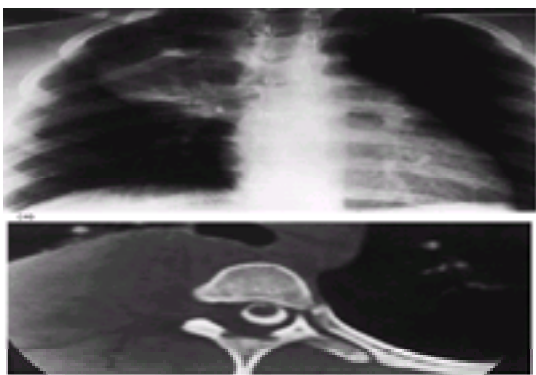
(a) Right posterior mediastinal mass with splaying of the third and fourth rib. (b) Detail of CT demonstrating mass in the right paravertebral gutter extending into the spinal canal. The neural foramen is widened.
